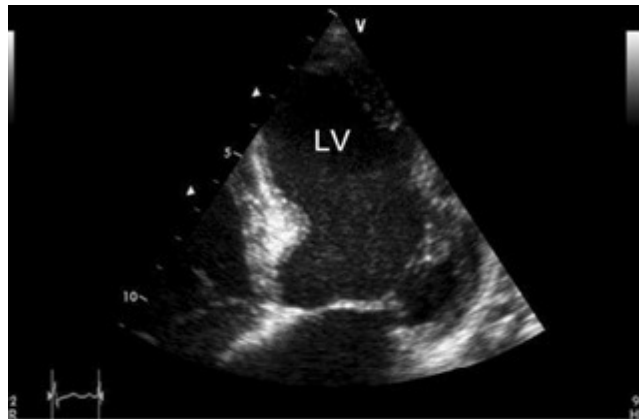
Diffuse SEC in LV in an apical 4 chamber in patient with DCMO (Kim and Park, 2009).
